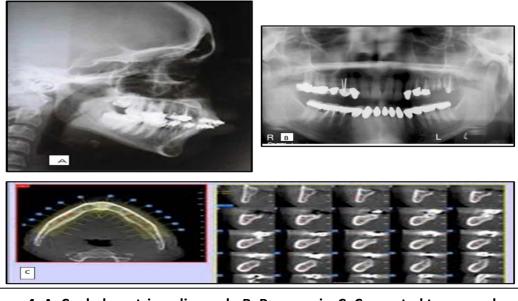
A. Cephalometric radiograph, B. Panoramic, C. Computed tomography
